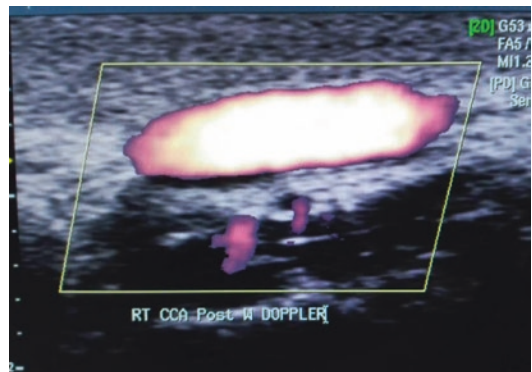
Power Doppler carotid artery
